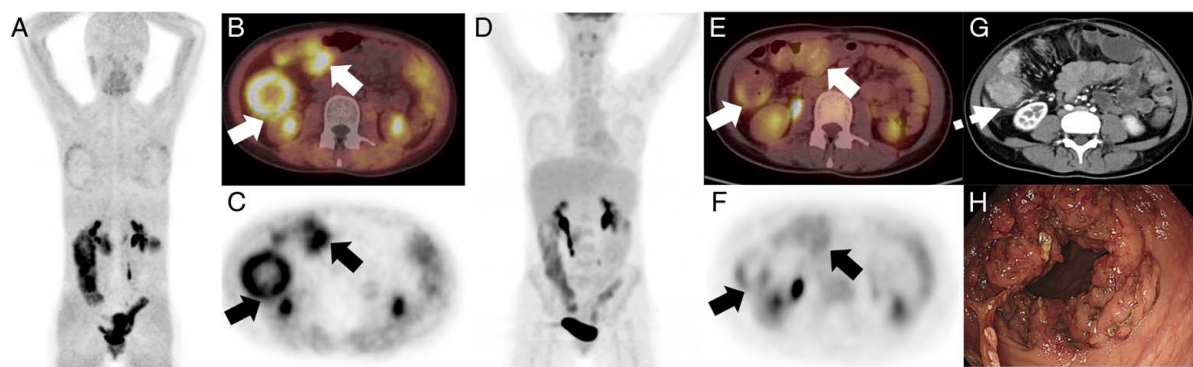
A 17-year-old man diagnosed with Crohn disease [Montreal classification A2L3B2P0, Crohn Disease Activity Index (CDAI) 376, simplified CDAI 9, simple endoscopic score for Crohn disease (SES-CD) 13]. The MIP of  $^{68}\text{Ga}$ -FAPI-04 PET (A) showed intense uptake of radioactivity in the abdomen. Axial fusion image (B) and axial PET (C) indicated the abnormal uptake was located in the terminal ileum and colon with wall thickening (SUVmax: 9.0, arrows). The MIP of  $^{18}\text{F}$ -FDG PET (D) showed FDG-avidity in the abdomen and increased uptake in bone marrow. The axial fusion image (E) and axial PET (F) of  $^{18}\text{F}$ -FDG PET/CT exhibited intense uptake in the involved bowels ( $^{18}\text{F}$ -FDG SUVmax: 10.8, arrows). Consistently, computed tomography enterography (CTE; G) showed wall thickening and hyperenhancement in the terminal ileum and colon, with strictures in the ileocecum (dotted arrow). The ileocolonoscopy showed mucosa edema and ulcers in the terminal ileum and colon (H).
